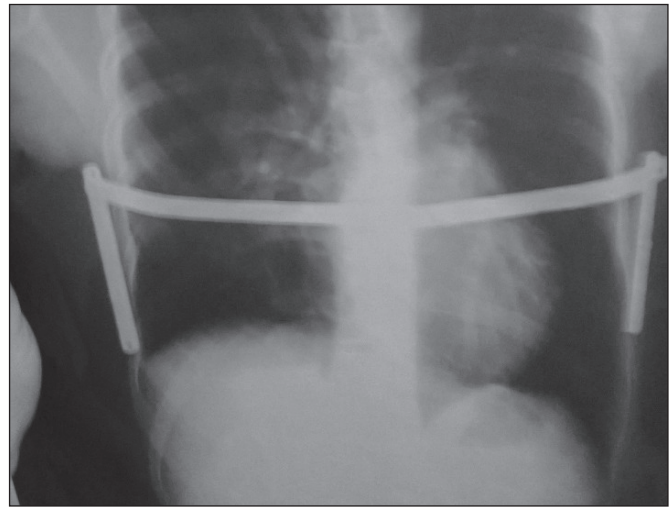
A postoperative chest radiograph of the same patient as in Fig. 1.23 showing the implant satisfactorily in position with no obvious evidence of intrathoracic injury.
